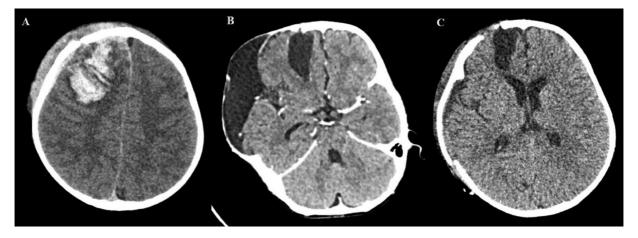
Subdural hygroma. Noncontrast CT head showing (A) elevated right frontal fracture extending to the base of the skull with right frontal lobe hemorrhagic contusion with significant mass effect and a midline shift of 8 mm. (B) Postcraniectomy with right subdural hygroma with no mass effect. (C) Subdural hygroma treated by early autologous cranioplasty.
